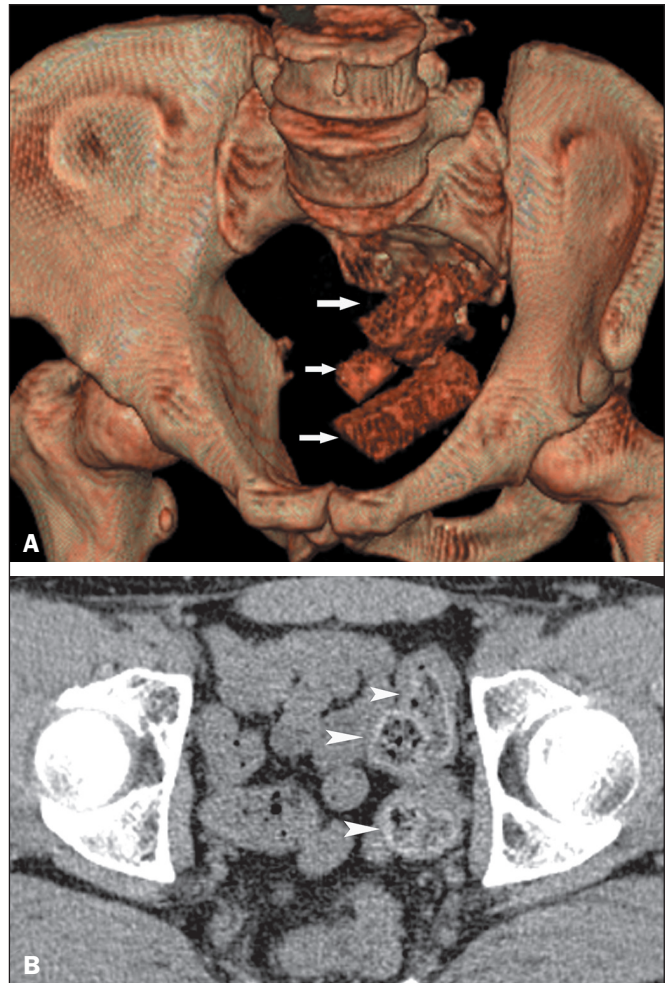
A 32-year-old male drug smuggler packing drugs to avoid arrest. A: Oblique volume-rendering CT image showing packets of drugs (arrows) purposefully deposited in the rectum. B: Axial CT image of the same drug smuggler, three years later, showing swallowed teabags stuffed with cocaine (arrowheads). Several drug packets were found in a stool analysis.
